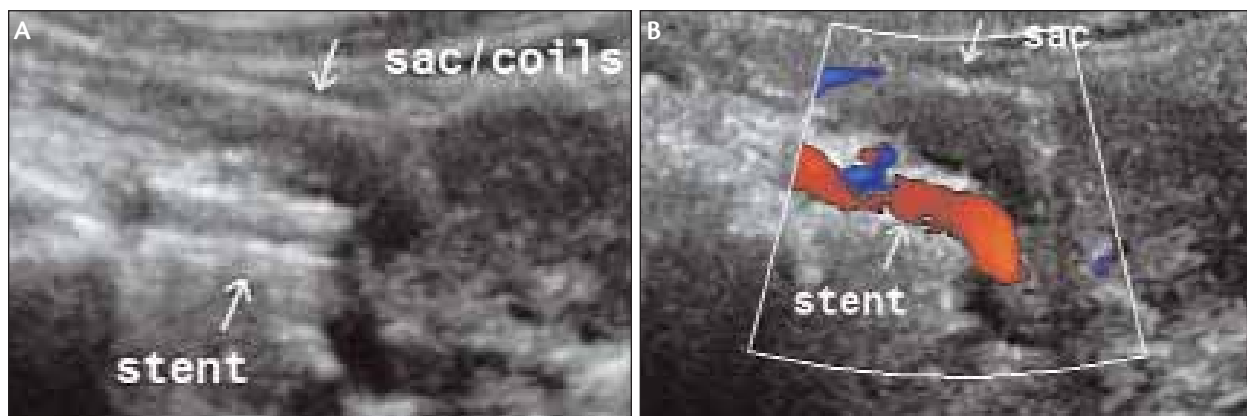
Duplex ultrasound without (A) and with (B) color flow showing patency of the left renal artery stent and no flow into the aneurysm sac.
